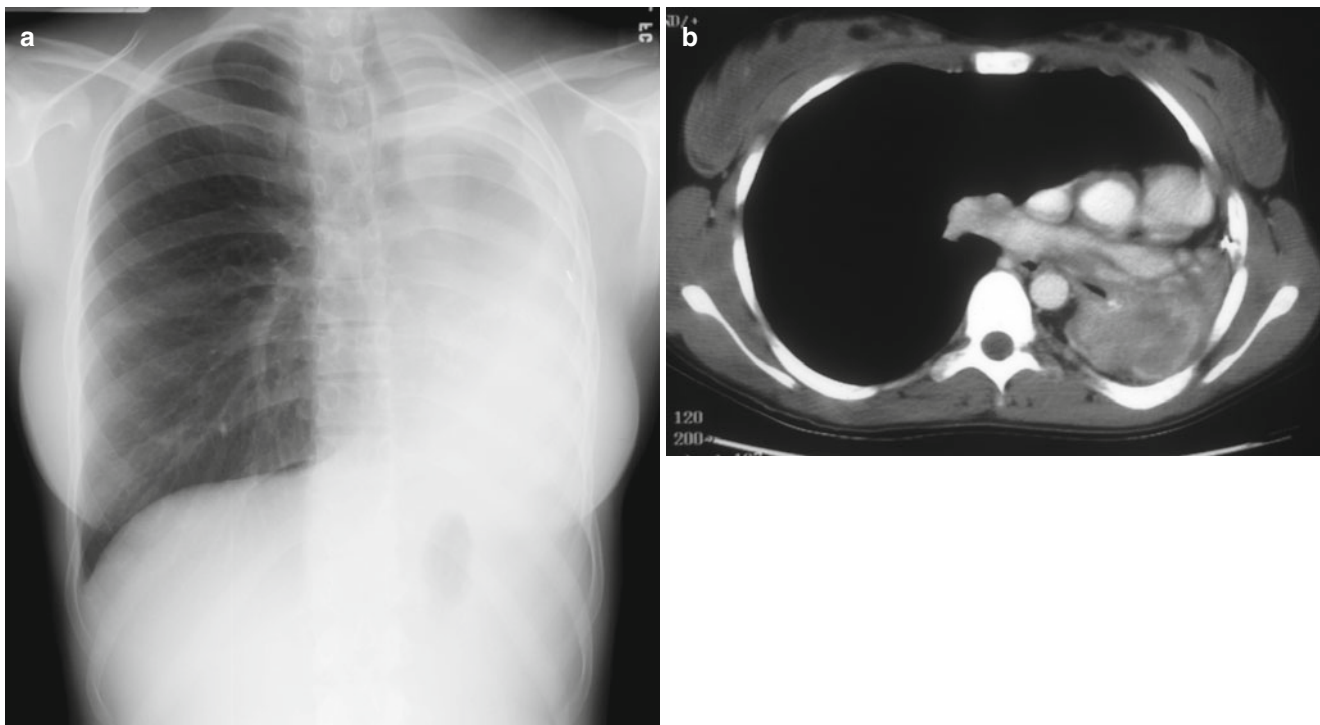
(a) Chest radiograph of an 18 year old female who presented with a 6-month history of increasing cough and shortness of breath and recent hemoptysis. Study revealed complete opacification of the left chest. (b) Subsequent computed tomography (CT scan) demonstrated
